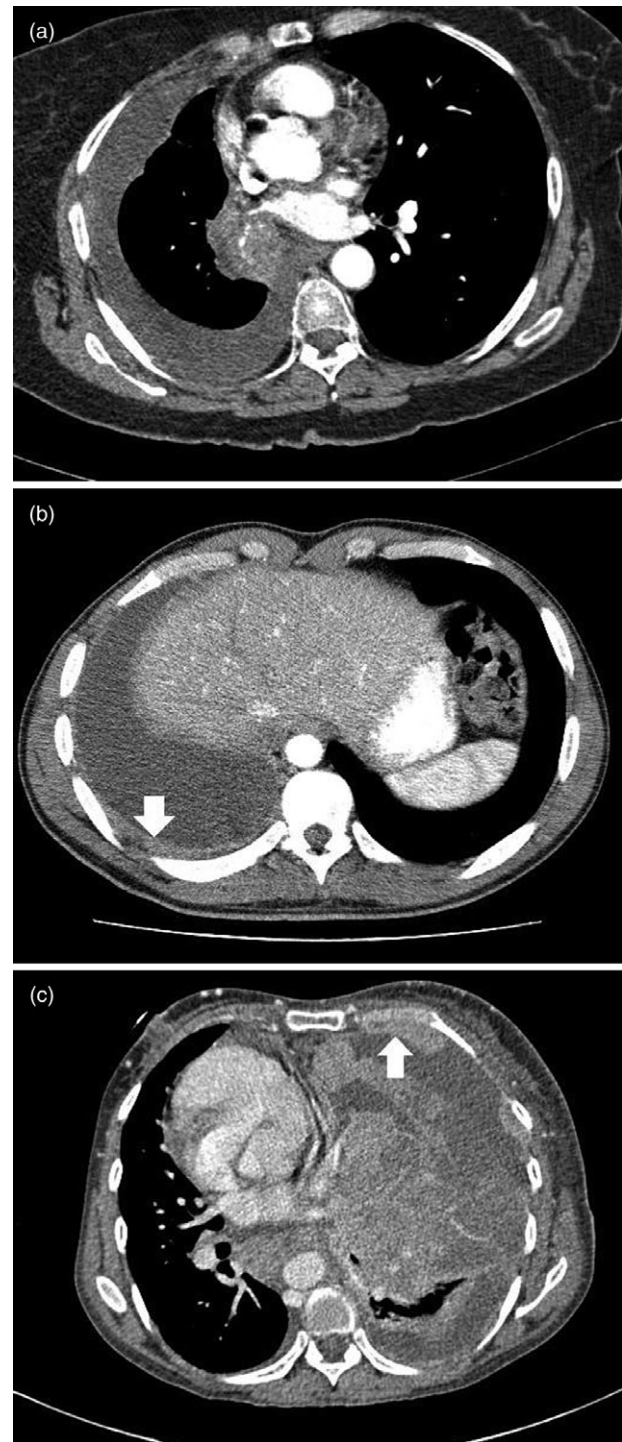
The pleura may have various appearances on CT scans of patients who present with pleural exudates and may guide the choice of biopsy technique and device. Note the presence of pleural effusions in association with (a) no pleural thickening (b) pleural thickening (arrow) and (c) a pleural based mass (arrow).
